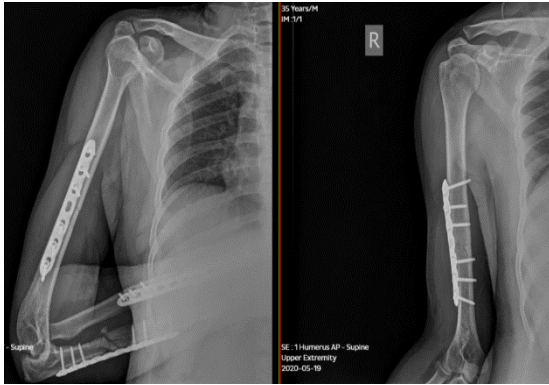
(a) two months follow-up radiograph showing healing of the fracture of the shaft of humerus
